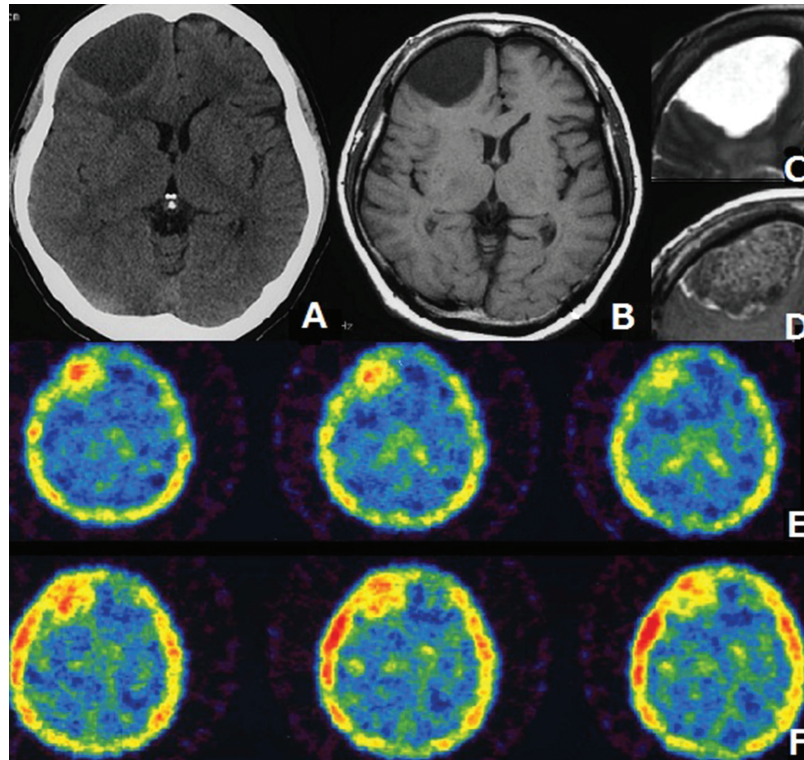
A: CT scan revealing a low-density lesion. B: T₁-weighted MRI showing a low-density lesion. C: T₂-weighted MRI showing a high-density lesion. D: Tumor showing an enhanced wall on enhanced T₁-weighted MRI. E: Early ²⁰¹Tl SPECT image showing high tumor uptake. F: Delayed ²⁰¹Tl SPECT image showing high tumor uptake. CT: computed tomography, MRI: magnetic resonance imaging, ²⁰¹Tl SPECT: Thallium-201 single-photon emission computed tomography.
